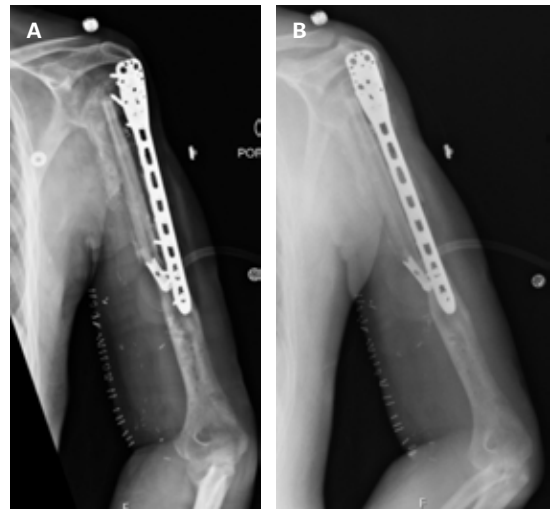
Left humerus x-rays after vascularized fibula graft. (A) AP and (B) lateral x-rays showing a lateral plate with screws. A large defect of the proximal humerus is filled with vascularized fibula graft. There is a plate remnant along the inferior margin of the bone graft. Severe glenohumeral arthritis is noted with evidence of remodeling.
